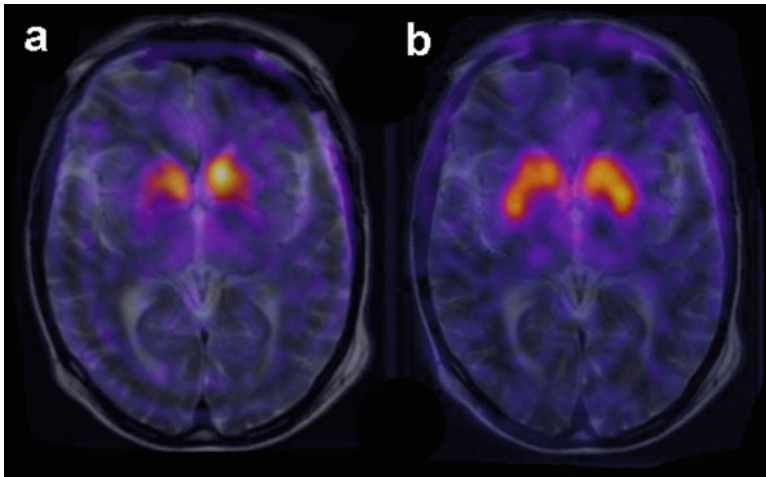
Dopaminergic function restoration in the putamen after bilateral delivery of AAV2-hAADC. Superimposition of MRI image and FMT-PET scan of a parkinsonian patient before (a) and 3 months after (b) receiving bilateral CED of AAV2-hAADC. Note the bilateral recovery of AADC activity in the putamen after AAV2-hAADC infusion compared to the low FMT signal (yellow) before the infusion
